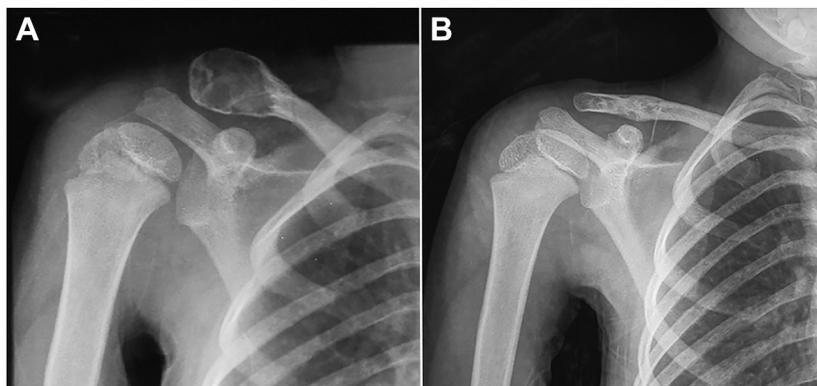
Anteroposterior radiographs of the shoulder of a 4-year-old boy with an aneurysmal bone cyst of the lateral end of the clavicle (case 1). (A) Before surgery. (B) Three years after extended curettage and bone grafting.
